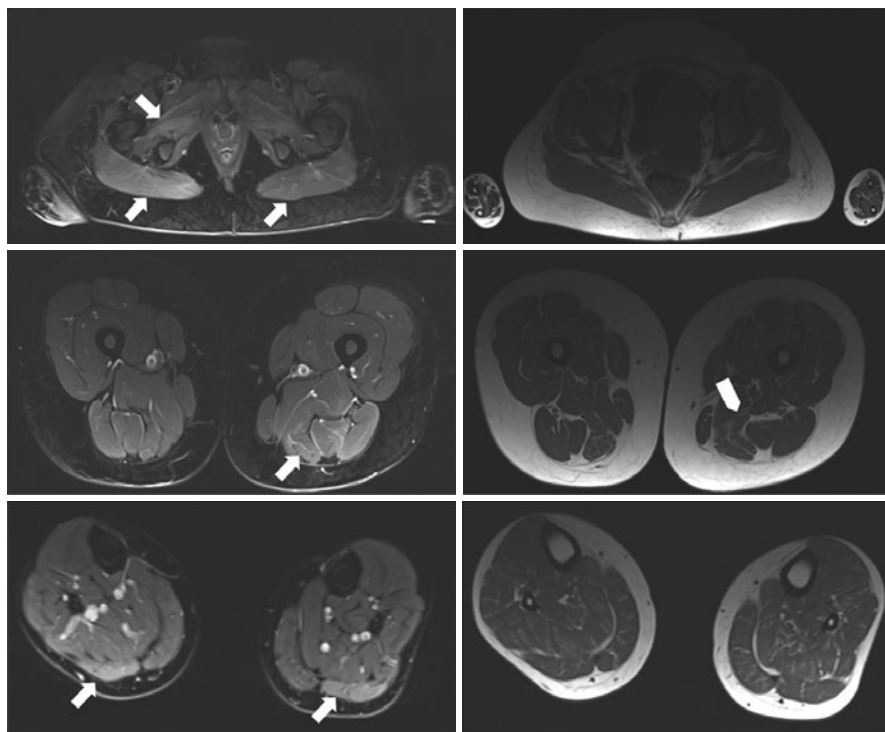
Axial images of lower limbs by T2 Dixon muscle MRI, left images display water-sensitive sequences, and right images fat-sensitive sequences. *Upper level:* white arrows show oedema in gluteus musculature bilaterally (left image). No fatty infiltration was shown (right image). *Middle level:* Oedema in hamstring musculature (left). Starting of fatty infiltration (right). *Lower level:* Oedema in gastrocnemius muscles bilaterally (left image). No fatty infiltration was found (right image)
